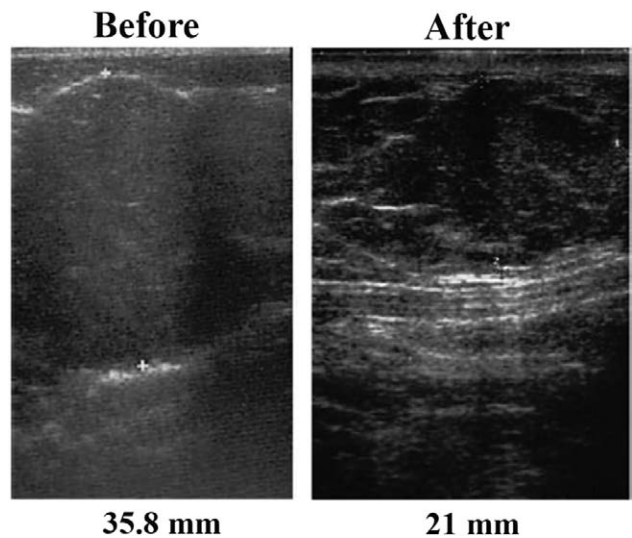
Ultrasound examination of adipose thickness: (A) pretreatment and (B) posttreatment at 1 month.
